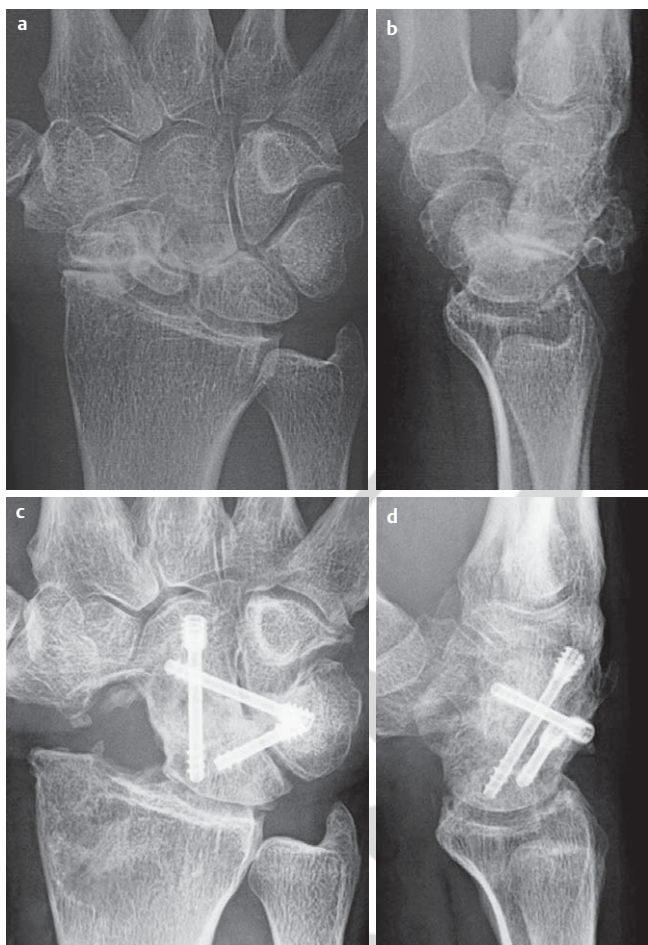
SNAC III. a, b Preoperative, c, d postoperative plain X-rays. [8], Copyright Dr. Piñal, 2012.
